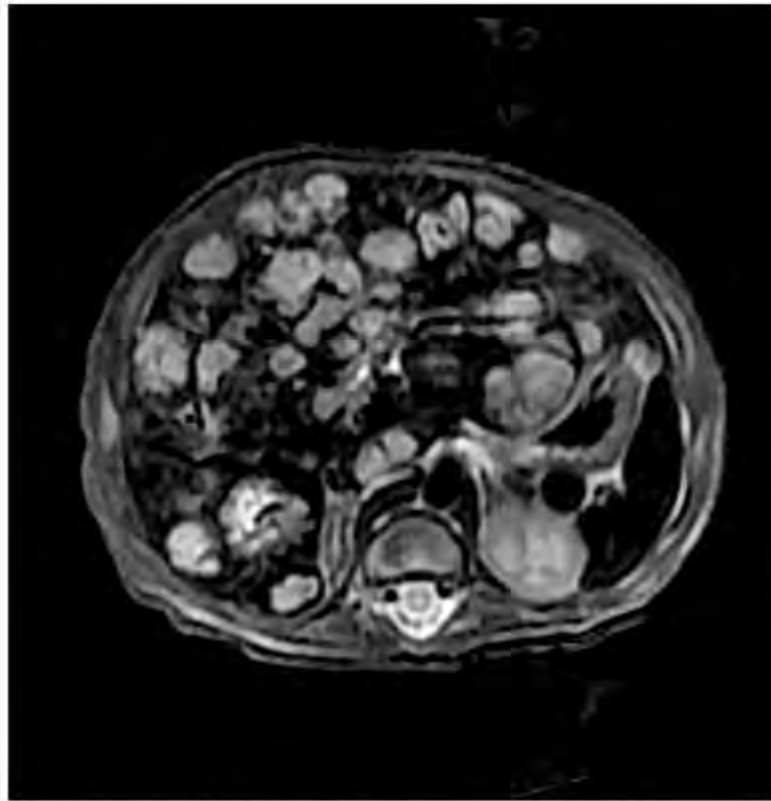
An axial T2 magnetic resonance image with fat saturation demonstrates multiple hyperintense lesions with near total hepatic parenchymal replacement.
